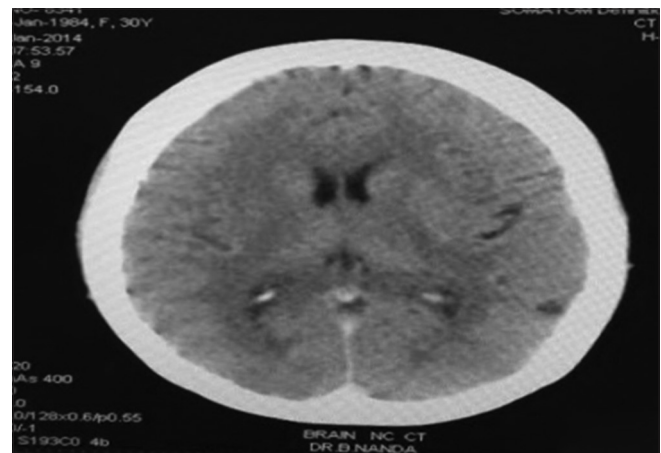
Non contrast CT Brain showed lacunar infarct left fronto-parietal cortex
